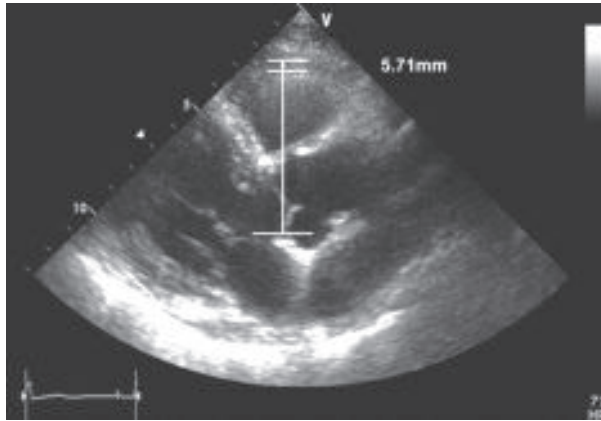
Example of measurement of epicardial fat thickness (EAT). Epicardial fat was identified as an echo-free space in the pericardial layers on the 2-dimensional echocardiography and its thickness was measured perpendicularly on the free wall of the right ventricle at end-diastole.
